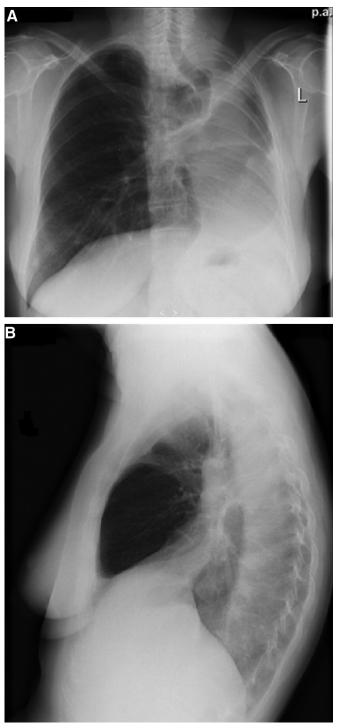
The patient's posteroanterior (*A*) and lateral (*B*) chest radiographs 102 months after left-sided pneumonectomy demonstrating extreme left-sided mediastinal shifting.
